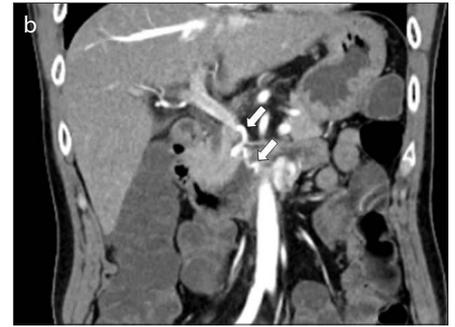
a, b. CT images in a 49-year-old man with duodenal GIST. Arterial phase axial image (a) shows a 2.8 cm hypervascular mass (*arrow*) with draining veins, which eventually drained into superior mesenteric vein, arising from the fourth part of the duodenum on coronal image (b, *arrows*).
